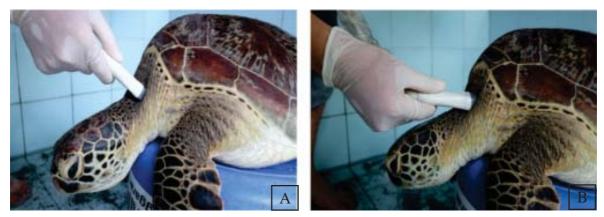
and 2B. Ultrasound evaluation of the cervical dorsal acoustic window (Fig 2A) Ultrasonography imaging was taken by Transverse 90°. (Fig 2B) Ultrasonogaphy <u>i</u>Imaging was Taken by Transverse 45°.
